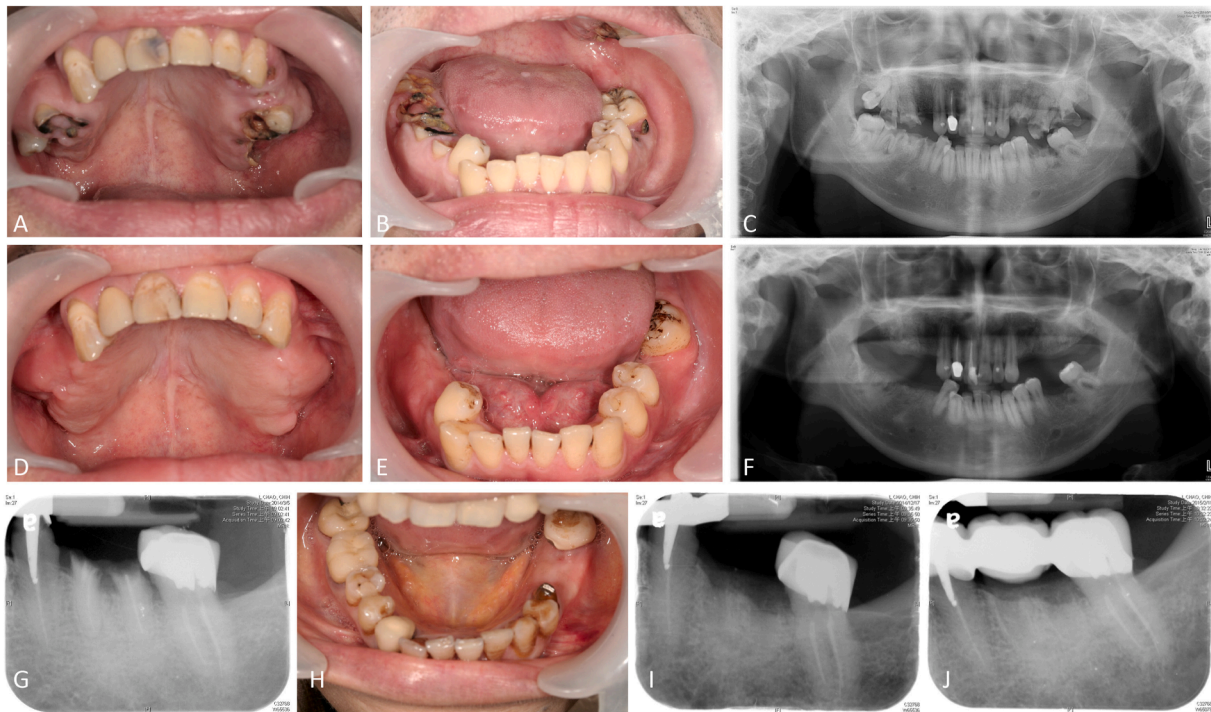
Examples of successful prevention of MRONJ after dental extractions by socket preservation with alloplast plus tetracycline in two high risk patients. A 23-year-old male with severe rheumatoid arthritis under methotrexate, prednisolone, tocilizumab and oral bisphosphonate therapy over 4 years (A–F) and a 58-year-old female with malignant lymphoma, rheumatoid arthritis and previous MRONJ of right maxilla due to treatment with prednisolone and zoledronic acid plus denosumab over 5 years (G–J). (A–C) Clinical photographs and panoramic radiograph in September 2014 showed eleven residual roots and two third molars that were needed extractions before making dentures. (D–F) Healing of all extraction sockets with complete epithelization and adequate bone regeneration within the grafted areas of four quarters under a sequent procedure during December 2014 to May 2015. (G) Periapical film in March 2014 showed residual roots of left lower first molar that was needed extraction before making a new bridge. (H and I) Complete healing of extraction socket with bone regeneration within the grafted area in December 2014. (J) Well bone formation below a new bridge in February 2015.
